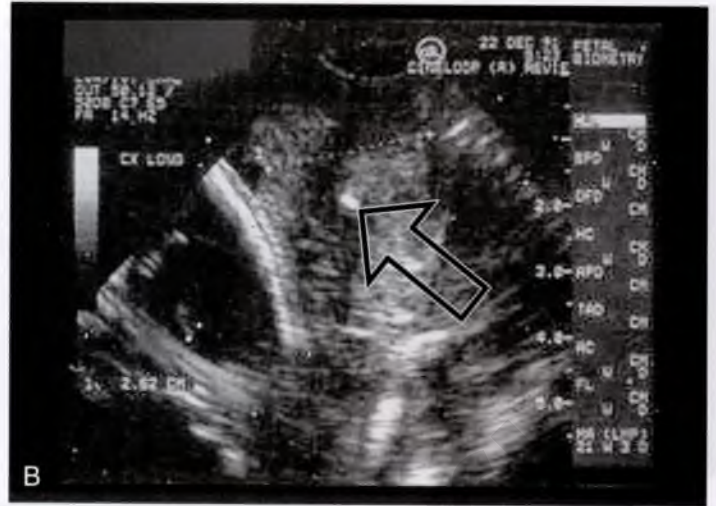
A. Ultrasonic view of a cervix detailing relative lengths before and after cervical suture placement. The cervix is less than 1 cm in length. The dilated os is at the arrows. Membranes (*M*) have prolapsed into the vagina. The fetal head is seen at *F*. B. The arrow points to the knot (white density) of the cervical stitch. Note that the length of the cervix has increased after placement of the suture.
